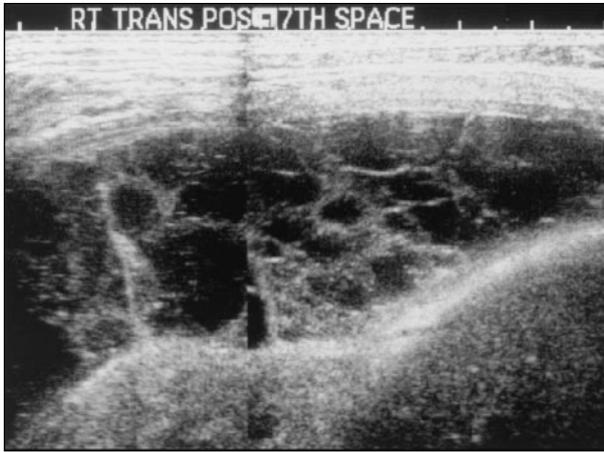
Ultrasonography of the pleura showing organized pleural fluid with multiple septae.
